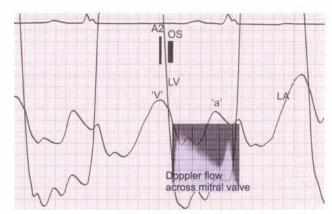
Hemodynamics of mitral valve stenosis: A cardiac catheterization tracing with simultaneous recording of left atrial (LA) with 'a' and 'v' waves and left ventricular (LV) waveforms is shown. A continuous wave Doppler record is superimposed during diastole; note the two peaks in flow acceleration-the second peak coincides with pre-systolic accentuation. The flow patterns reflect the pressure gradients across the mitral valve in diastole. A2 aortic component of second heart sound; OS opening snap
